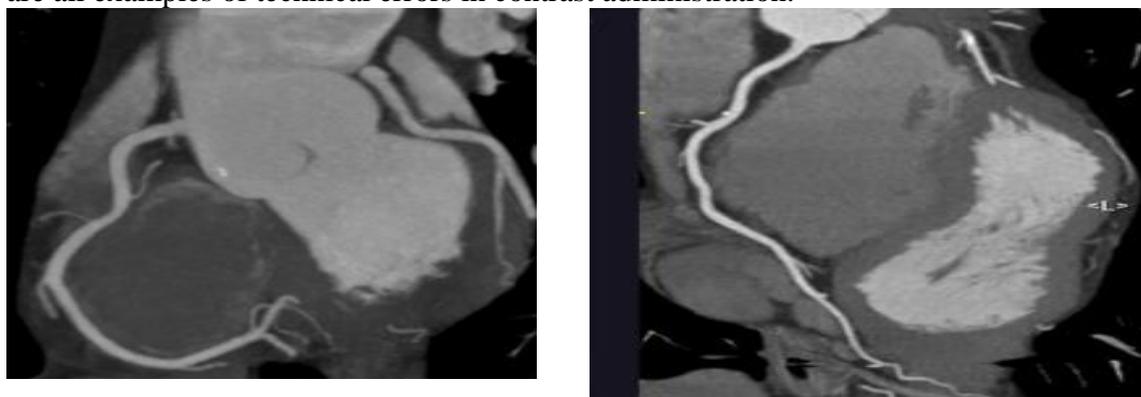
Curved planar CT image shows low contrast attenuation With high noise (1st image) and optimum timing with high contrast attenuation (2nd image). (28)
